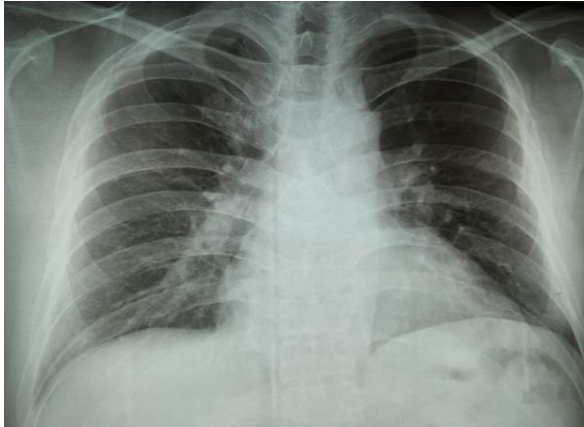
Chest X-ray P/A view showing mild cardiomegaly with prominent right pulmonary artery
